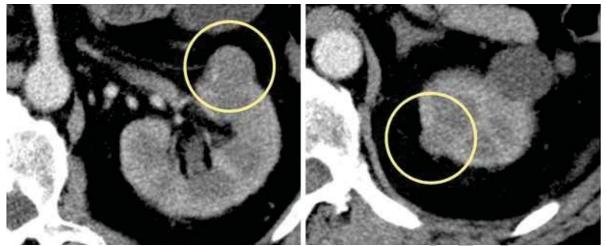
Computed tomography scan revealing a 2.2 cm enhancing lesion in the anterior mid-pole and a 1.6 cm enhancing lesion in the postero-medial lower pole.
